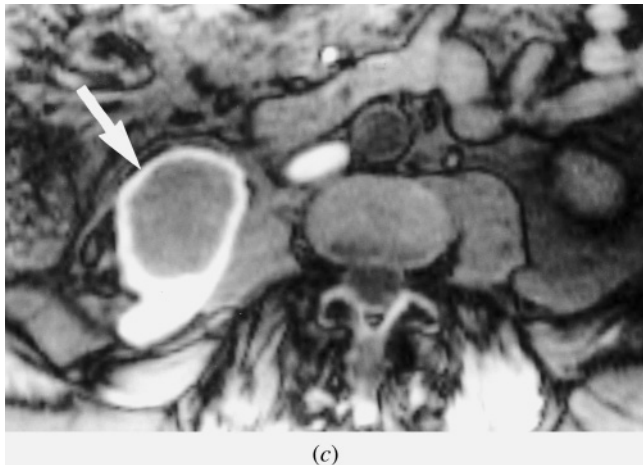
(Continued) because of rescaling of abdominal tissue signal intensities. T1-weighted precontrast fat-suppressed SGE (c) and sagittal 3-min T1-weighted fat-suppressed postgadolinium SGE (d) images in a second patient. A large mass arises in the upper pole of the right kidney. The tumor is heterogeneous on the 3-min postgadolinium image (arrow, d). The tumor has resulted in a large perinephric hematoma that has extended inferiorly in the pararenal space (arrow, c). The peripheral rim of high signal on the noncontrast T1-weighted image is diagnostic for hemorrhage. Transverse T1-weighted fat-suppressed 3D-GE (e) and transverse hepatic venous-phase (f) and interstitial-phase (g) fat-suppressed 3D-GE images demonstrate renal cancer with subcapsular and perirenal hemorrhage in the right kidney in another patient. The tumor (arrows, f, g) shows heterogeneous progressive enhancement on postgadolinium images (f, g). A subcapsular hematoma (*, e-g) with perirenal extension is detected. The peripheral high signal intensity of the hematoma reflects its subacute nature.
